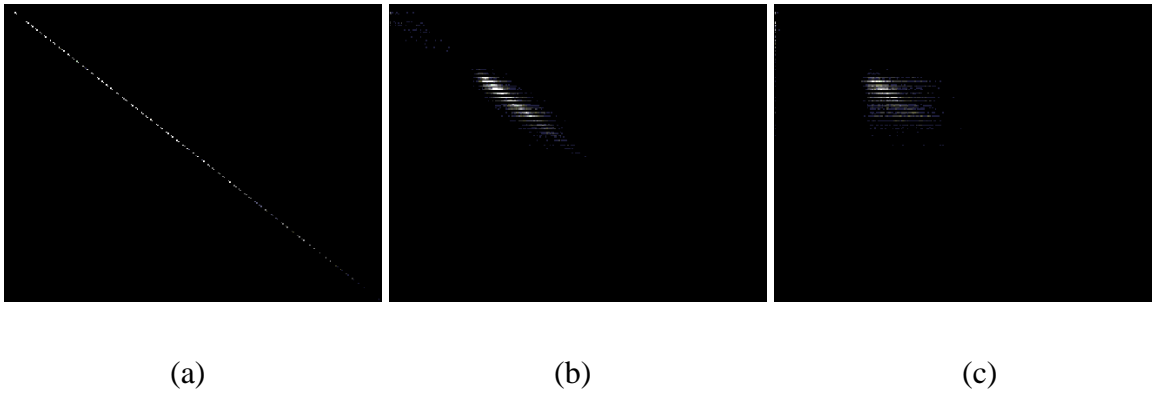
Example 2D joint entropy histogram of (a) Identical MR images of the head, (b) floating image was rotated 1° , and (c) floating image was rotated 5° .
